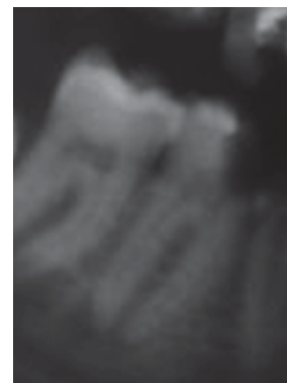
Digitized intraalveolar periapical radiograph (3.6.)
